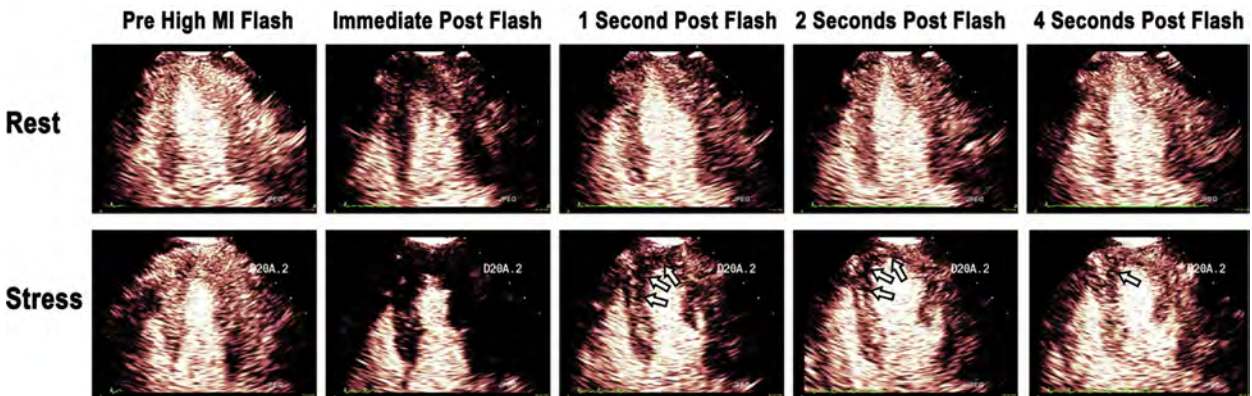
An example of a stress-induced perfusion defect in the left anterior descending coronary artery (LAD) territory (*arrows*). Note that end-systolic replenishment within the LAD territory in the apical four-chamber window is normal under resting conditions but delayed in the LAD territory (*arrows*) during dobutamine stress imaging.
